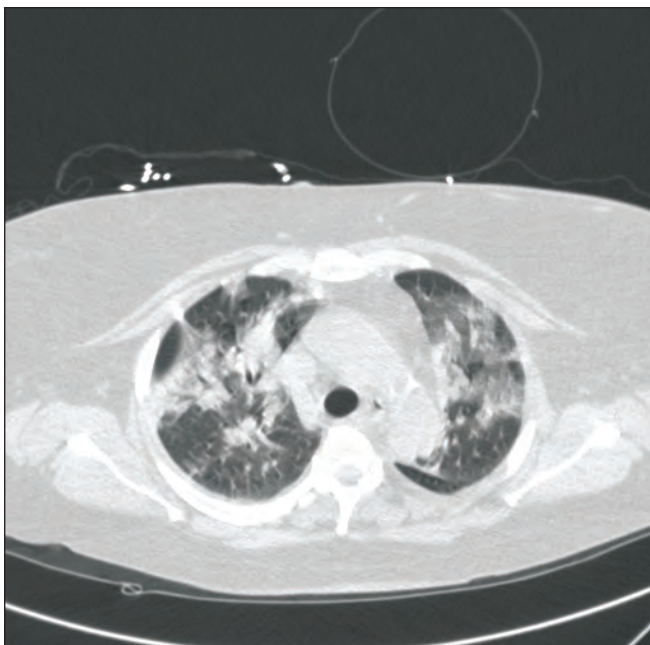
CT scan showing bilateral infiltrative disease
